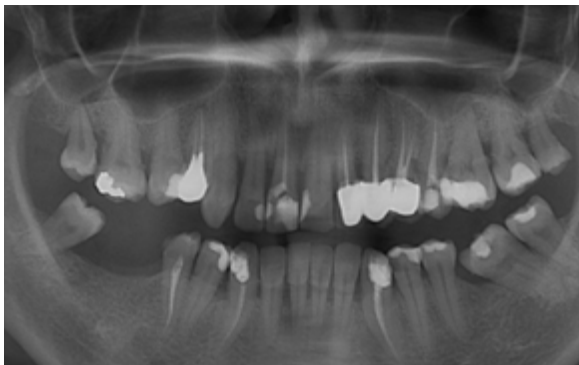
Radiograph aspect - horizontal bone atrophy with localized vertical resorption.
